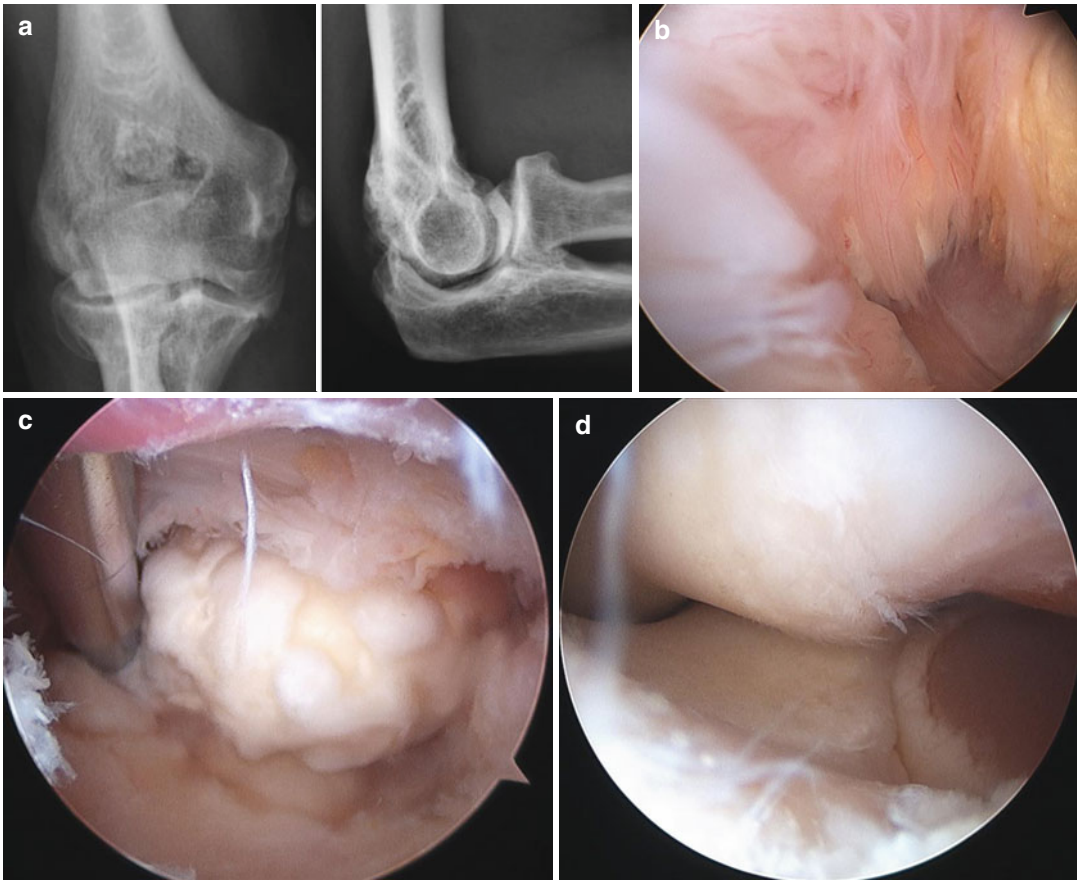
(a–c) Secondary synovial chondromatosis. (a) AP and lateral radiographs of the right dominant elbow of a 49-year-old male patient. Multiple loose bodies can be seen in the posterior compartment more clearly on the AP projection. (b) Arthroscopy of the posterior compartment revealed a nest-like arrangement of multiple loose bodies and synovitis similar to the appearances of PSC. (c)
